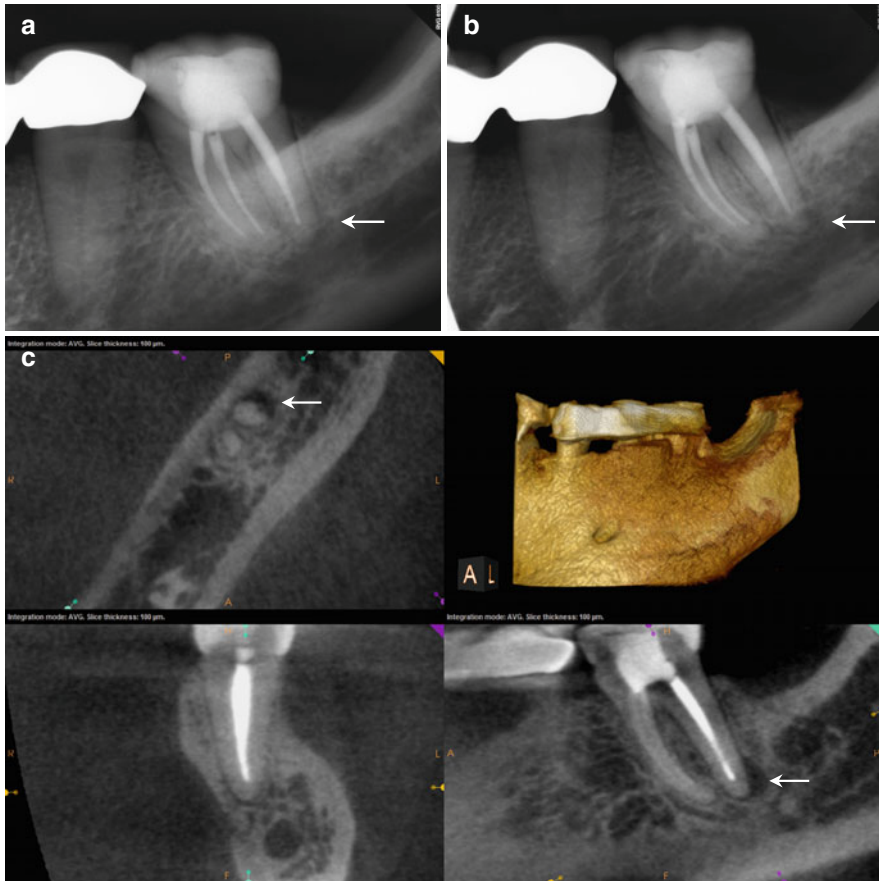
(a, b) Preoperative radiographs reveal adequate root canal fillings, but a faint area at the distal aspect of the distal root apex is evident in both images (*white arrows*). (c) The axial and sagittal sections demonstrate a small area of low density at the distal aspect of the distal root apex; this most likely is the result of tissue remaining in the dilacerated portion of the canal that has not been negotiated and debrided (*white arrows*). Slice-by-slice examination of the sagittal sections discloses the angle and direction of this short canal segment. The mesial canals appear underextended as well. (d) The colorized version of the sagittal section has been magnified to highlight the periapical area (*yellow arrows*) as well as the dilacerated canal path (*red arrow*). (e) Working length radiograph after harvesting the gutta-percha in the distal canal, confirming the negotiation of the file to the minor constriction. The remaining root canal filling materials were removed, and the canals re-instrumented as well. (f, g) Final radiographs showing the extension of the filling material into the distal dilacerations and the extended mesial canals. (h) 12-month recall scan showing resolution of the distal low-density area. The patient remains asymptomatic. (i) The colorized sagittal section at the 12-month recall: note the resolution of the distal area as compared to (d)
